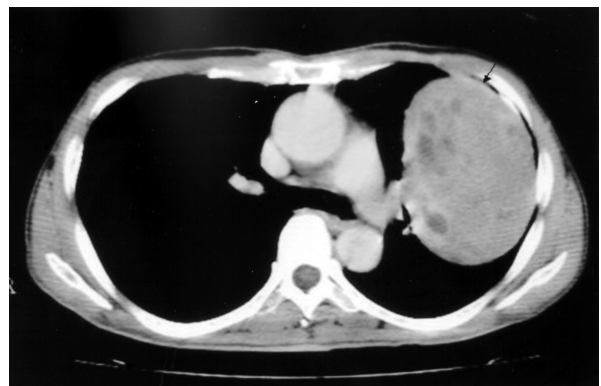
Heterogenous pattern of the tumor after contrast medium infusion on chest CT image.
